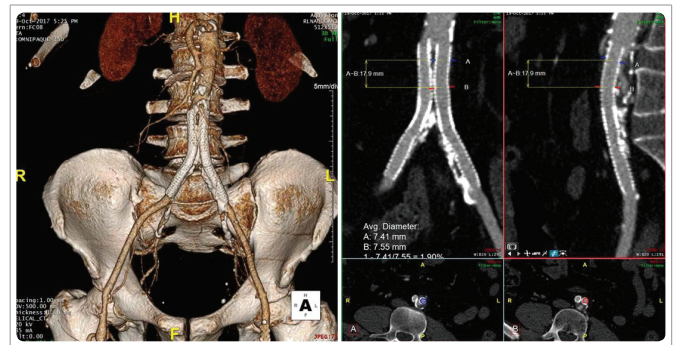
1-year CT-Angiogram follow-up study.
